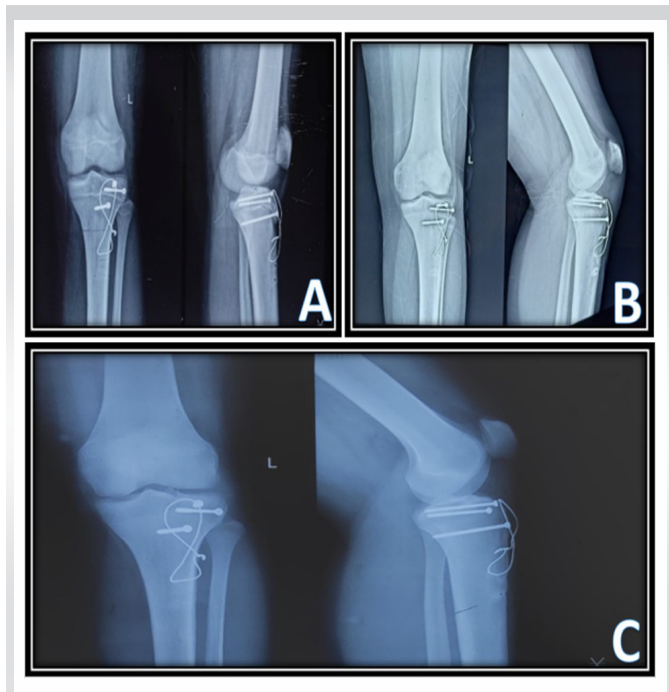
Follow-up radiographs showing signs of fracture union and remodeling at (a) one-month, (b) 6 months, and (c) 1 year.
